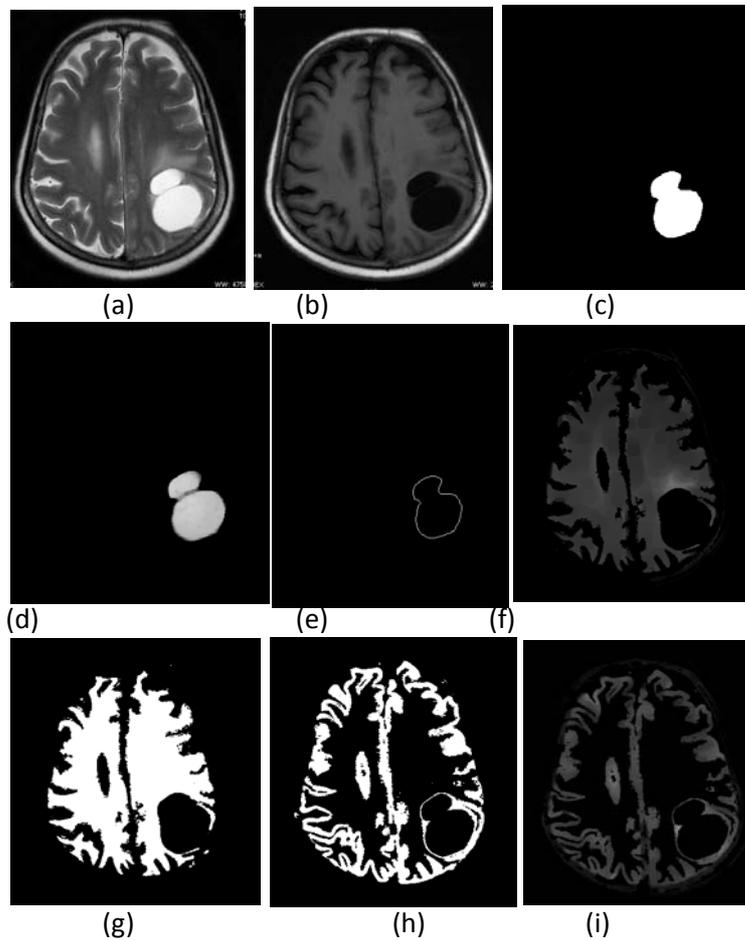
Example of segmented ROIs of high grade glioma tumor patient from MR image slices. a) T1 FLAIR image b) T2 weighted image c) Segmented binary tumor d) Gray level tumor e) Extracted tumor boundary f) Gray level WM g) Binary segmented WM with outer layers removed h) Segmented binary GM i) Gray level GM with outer layers removed
